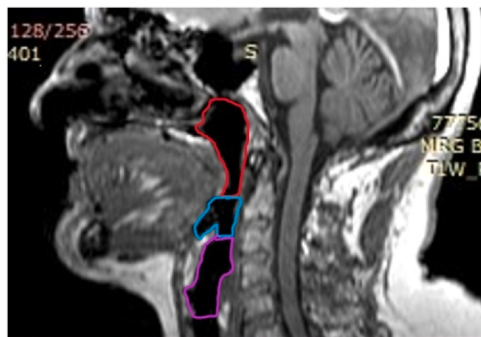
Sagittal plane T1-weighted MRI; nasopharynx (red area), oropharynx (blue area), and hypopharynx (purple area). MRI, magnetic resonance image; T1, in MRI refers to T1 relaxation time.
